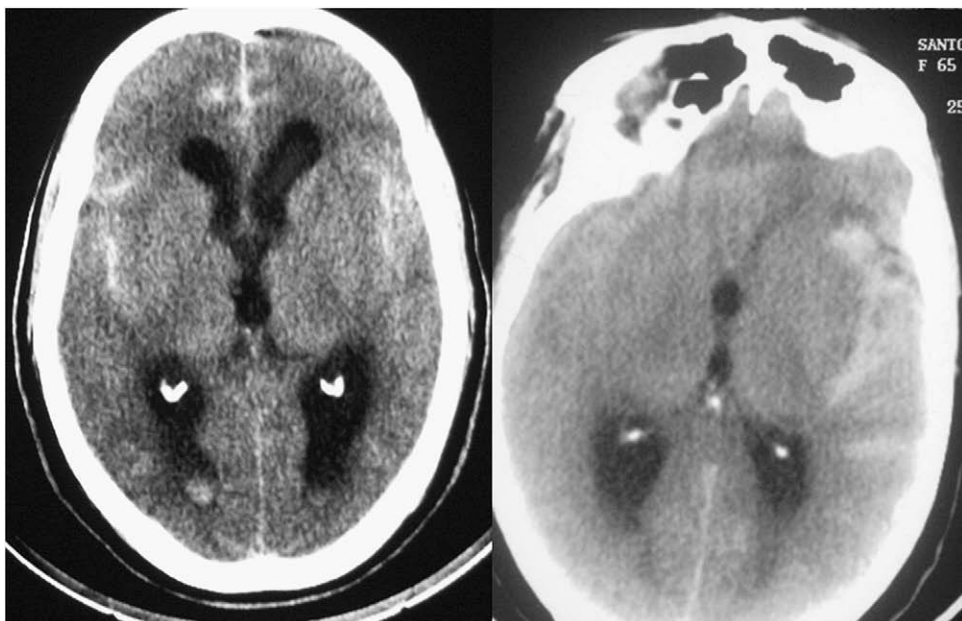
Computed tomographic scans showing the pattern of SAH in patients with n-PMN SAH.
